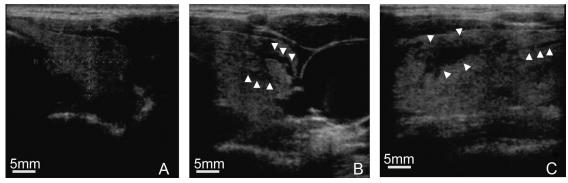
Paroxysmal thyroid swelling detected by ultrasound. The left thyroid lobe thickened from 12.5 mm (A) to 20.2 mm during a spell (B). Hypoechoic areas, indicated by *arrowheads*, are apparent during a spell (B and C).
